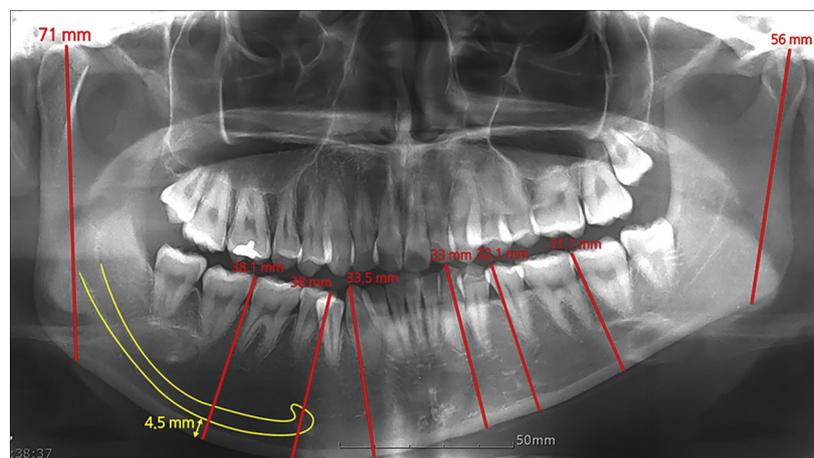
Panoramic radiograph showing measurements of ramus, body, symphyseal region and vertical depth of bone between the nerve and lower border of the mandible.
